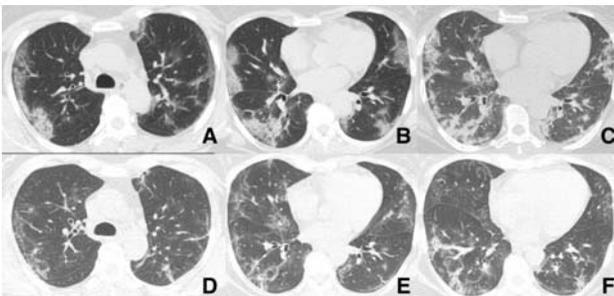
CT images of a 43-year-old female healthcare worker with COVID-19. CT study at presentation (A,B,C) and after 14 days (D,E,F) from the initial scan are depicted. She presented with 6 days history of cough and fever. Note temporal resolution of parenchymal changes from GGO at presentation to subpleural residual band like opacities. Her symptoms had also resolved (similar to the resolution of CT changes) and she was discharged following the second CT.
